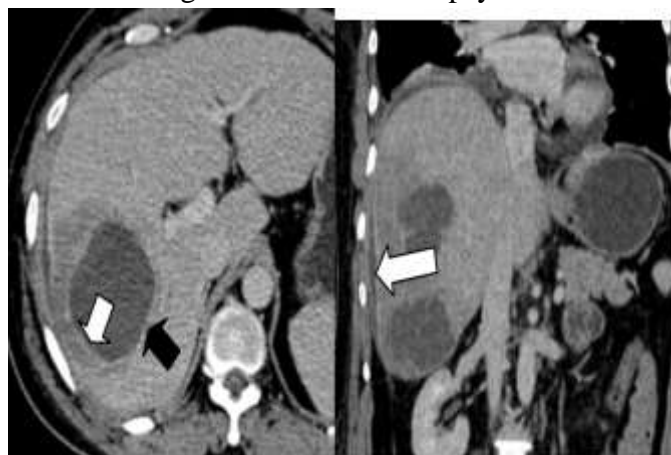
Contrast-enhanced CT scan demonstrates two large, lobulated, well-defined cystic mass in the right hepatic lobe showing peripheral enhancement (white arrow), however there is another thin hypoattenuating rim(Black arrow) outside the enhancing rim with ill-defined
